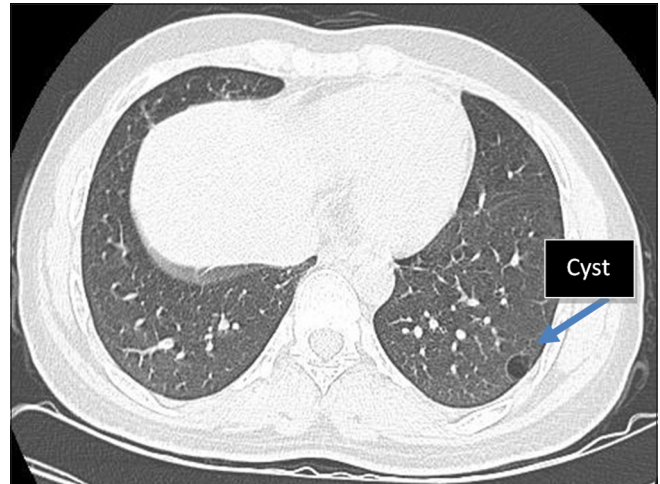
Axial computed tomography image of the chest shows small thin-walled cyst in posterior basal segment of the left lower lobe.
